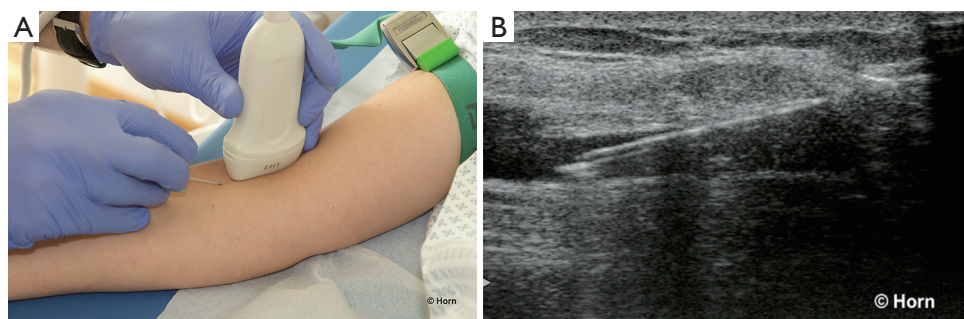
Longitudinal approach. (A) Insertion of the needle along the long axis of the US transducer; (B) RTUS visualization of the needle course. US, ultrasound; RTUS, real time US.
